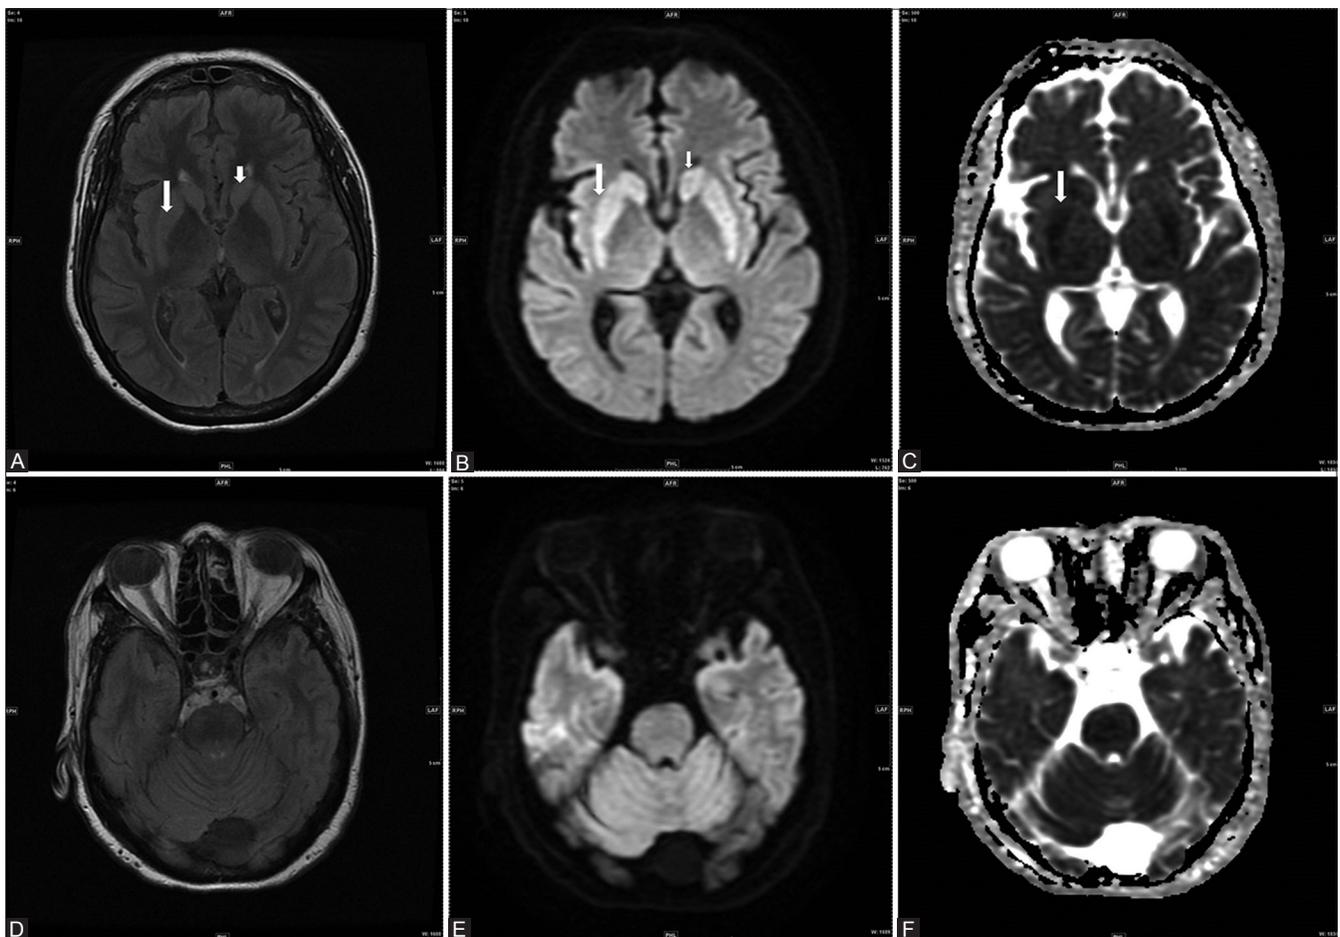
Case 1 (1st MRI - 3 days after correction of hyponatremia) (A) Axial FLAIR section at the level of basal ganglia shows subtle hyperintense signal in both the caudate nuclei and putamina (B) Axial DWI section at the level of basal ganglia shows hyperintense signal in both caudate heads and putamina suggestive of diffusion restriction (C) Axial ADC map at the level of basal ganglia shows low ADC values in both caudate heads and putamina suggestive of extrapontine myelinolysis (D) Axial FLAIR section at the level of pons shows no significant signal change (E) Axial DWI section at the level of pons shows no diffusion restriction (F) Axial ADC map at the level of pons shows no diffusion restriction
